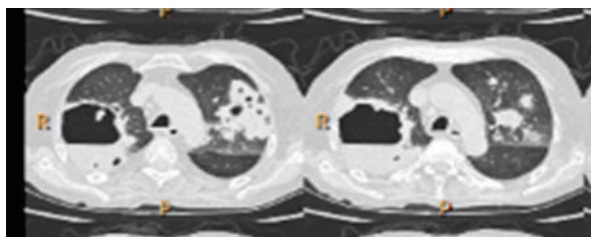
HRCT Shows Active Infective Aetiology In Form Of Cavitary Lesion With Internal Air Fluid Levels - Lung Abscess.
